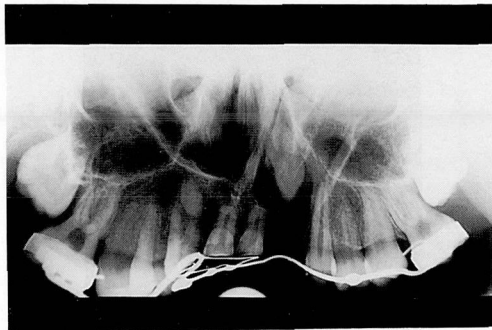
Radiograph representing the presurgical condition.
